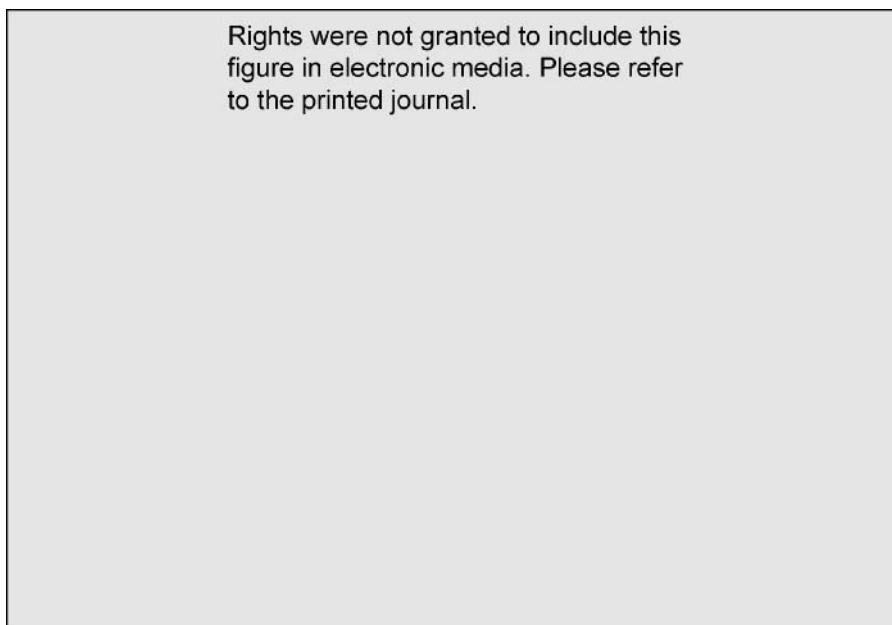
A, Week 0 vertex view of a patient with androgenetic alopecia. B, Week 24 vertex view showing efficacy of therapy. (Courtesy of Ronald C. Savin, MD, New Haven, CT.)
